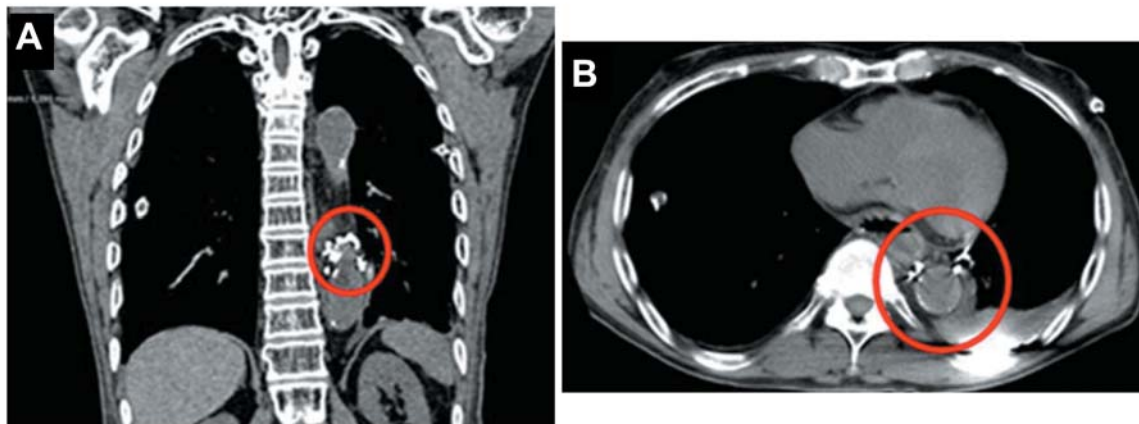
Coronal (A) and axial (B) sections by computed tomography obtained 50 min after starting the injection shows leakage (circle) of the lipiodol in the left hilar area.
